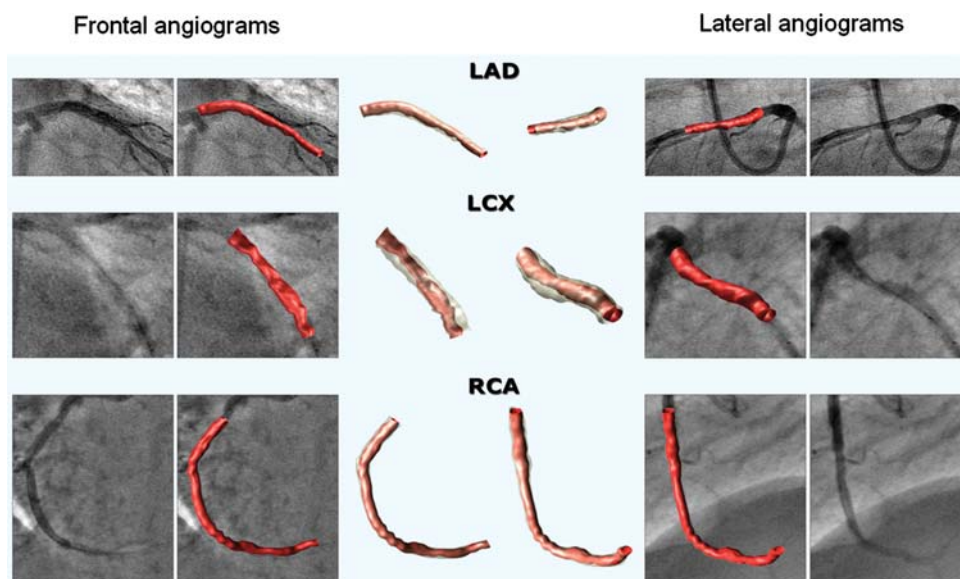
Three-dimensional (3D) reconstruction of human coronary arteries based on fusion of biplane angiography and intravascular ultrasound^{10,11} Central panels show 3D reconstruction of left anterior descending artery (LAD), right coronary artery (RCA), and left circumflex (LCX) depicted in the same orientation as the frontal and lateral biplane angiograms. Left and right panels show the frontal and lateral biplane angiograms of the coronary arteries, respectively.
